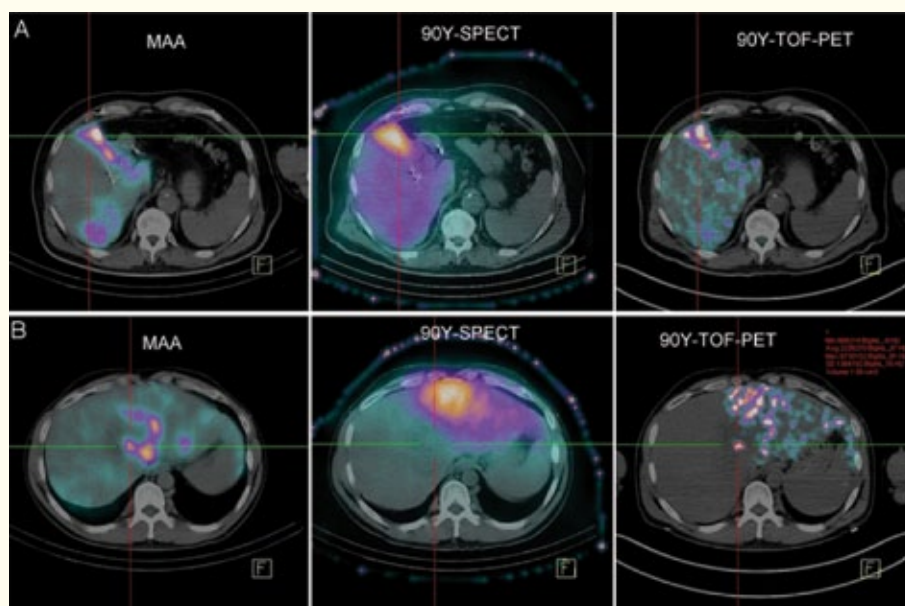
Different imaging techniques at the example of two patients (A on top, B on bottom) that were treated with ⁹⁰Y microspheres for radioembolisation of hepatic tumours. The left image shows ^{99m}Tc-MAA prior to treatment, the middle image ⁹⁰Y-Bremsstrahlung-SPECT and the right ⁹⁰Y-TOF-PET. The images were taken from Figure 7 of Th. Carlier *et al.*, *EJNMMI Research* 2013; 3: 11 (Springer Open Access Licence, Creative Commons Attribution Licence).
